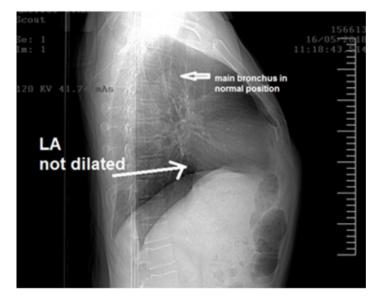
Chest X-ray of the thorax. Lateral view. The left atrium is a posterior structure and in case of dilation it will modify the position of the main bronchus. In this image LA is nod dilated and the main bronchus is in normal position.
